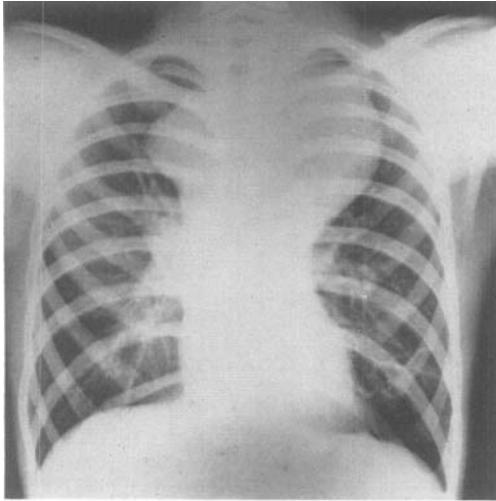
Case 1. Postero-anterior radiograph.
